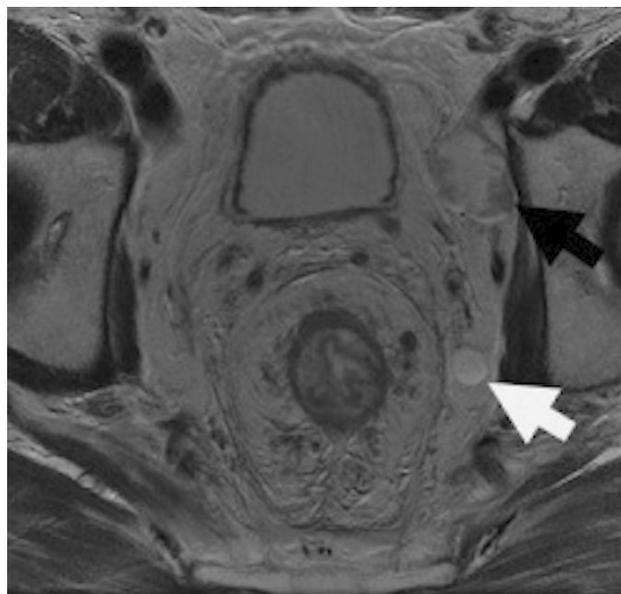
Pretreatment pelvic MRI of patient with locally advanced rectal cancer with enlarged lateral lymph nodes with (black arrow) and without (white arrow) malignant features
